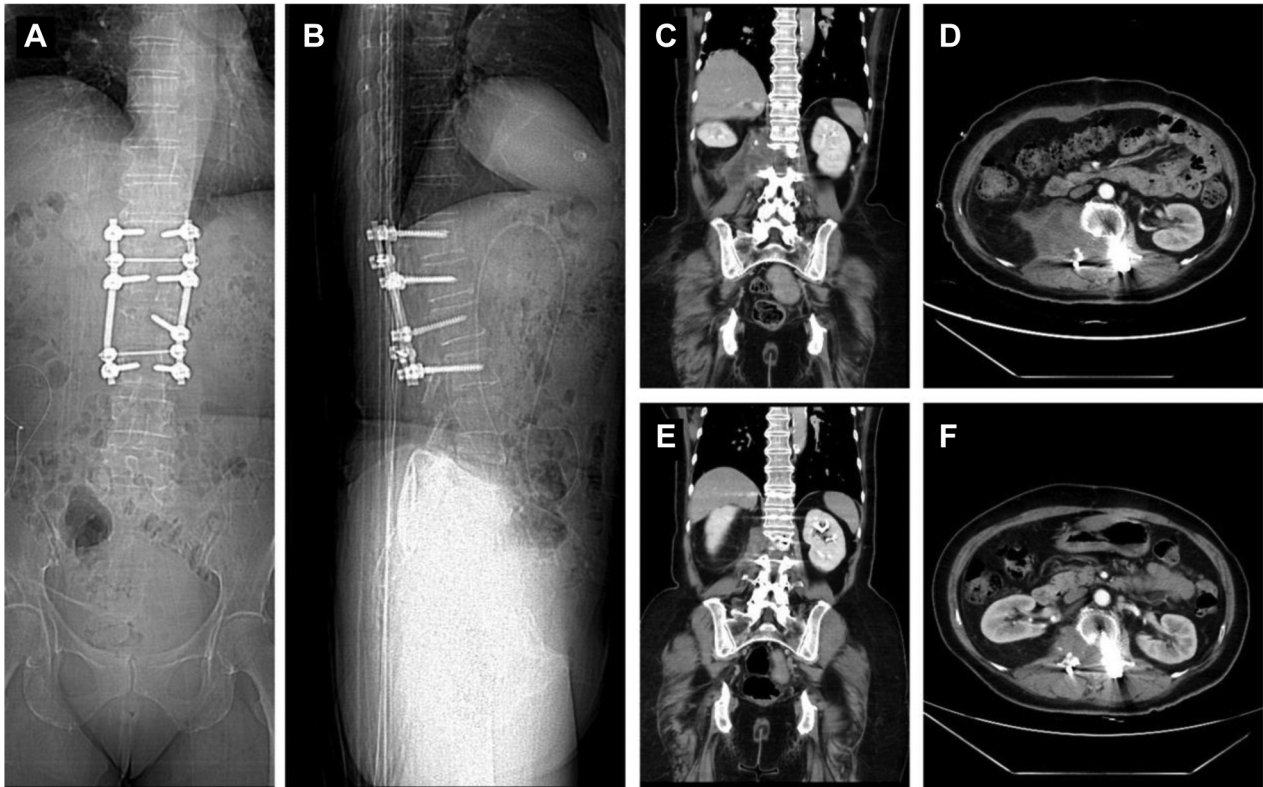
Post-operative abdominal CT revealed a residual mass lesion with good position of the instrument. (A-D) Post-operative day 7. (E and F) Post-operative 4 months. CT: Computed tomography.
